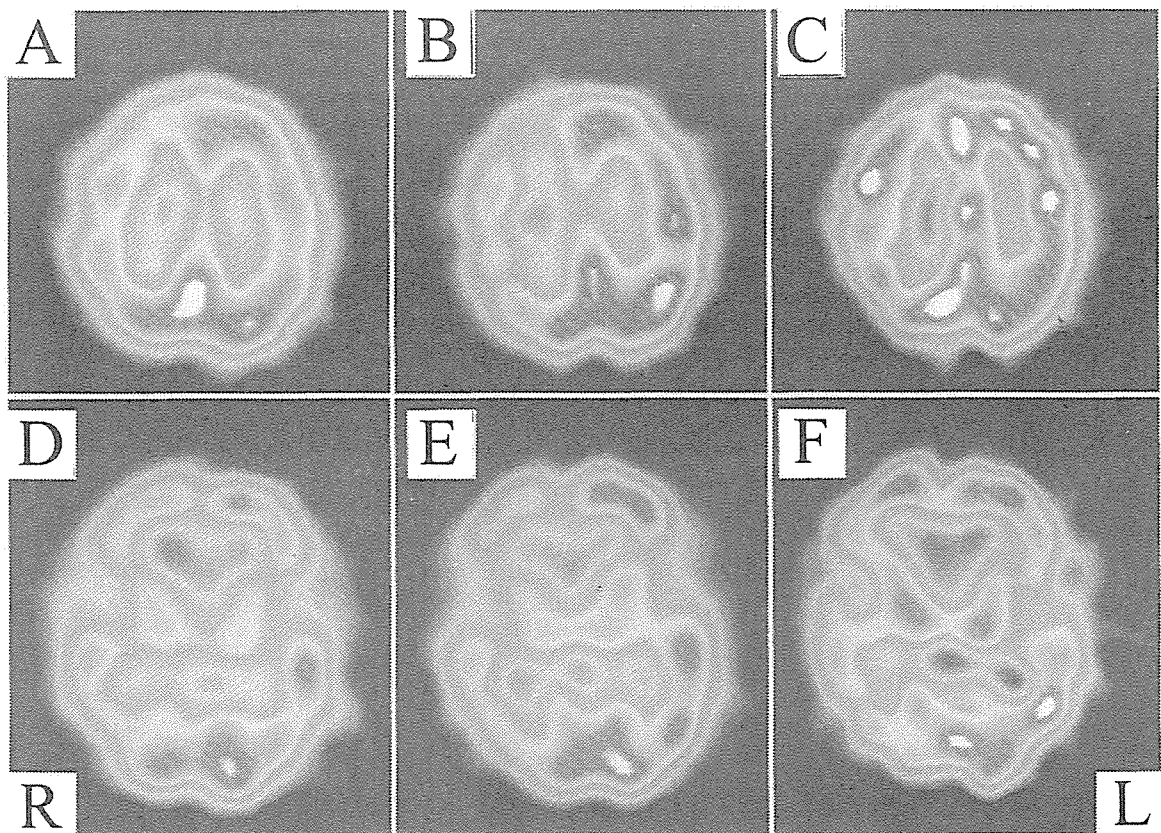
Case 1. A and D: Preoperative <sup>123</sup>I-IMP SPECT scans demonstrating severe hypoperfusion in the right hemisphere including the basal ganglia. B and E: Preoperative <sup>123</sup>I-IMP SPECT scans obtained after acetazolamide infusion, showing a marked decrease in the vascular reserve in the right hemisphere including the basal ganglia. C and F: Postoperative <sup>123</sup>I-IMP SPECT scans demonstrating improvement in the CBF in the right hemisphere including the basal ganglia.
